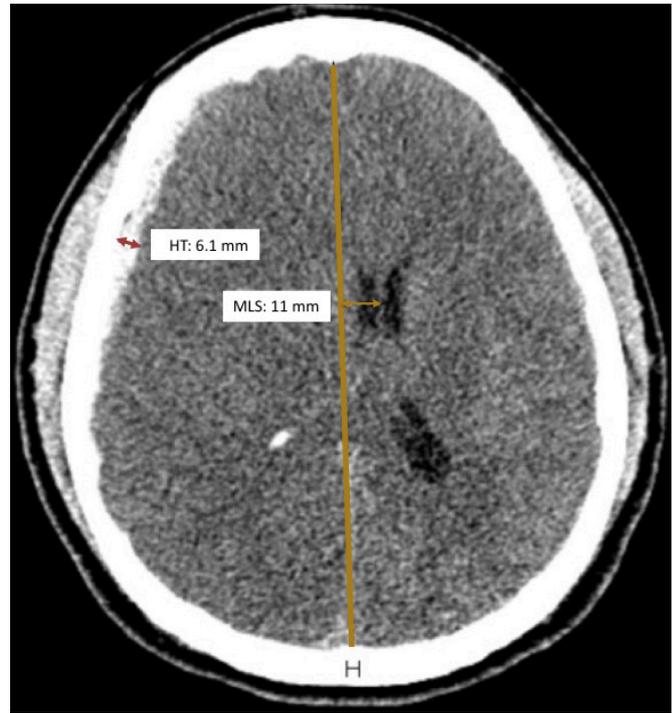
The thickness of the acute subdural hematoma (red arrow) was measured on a CT scan as the largest distance between the cortex and the internal table; midline, orange line; midline shift, orange arrow. HT, hematoma thickness; MLS, midline shift.
